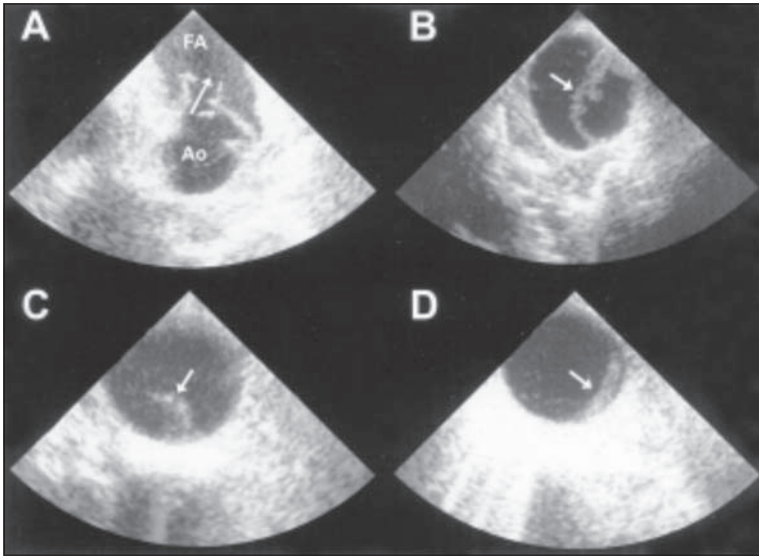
Transesophageal echographic aspect of main categories of traumatic injury. A) Traumatic aortic rupture with false aneurysm (FA) communicating (arrow) with the aortic lumen (Ao); B) traumatic aortic rupture with a large medial flap; C) intimal flap without hemomediastinum or modification in the aortic geometry; D) intramural hematoma (arrow) without hemomediastinum. (Reprinted from ref. 30; Goarin JP, Cluzel P, Gosgnach M et al. Evaluation of transesophageal echocardiography for diagnosis of traumatic aortic injury. *Anesthesiology* 2000; 93:1373-7.)
